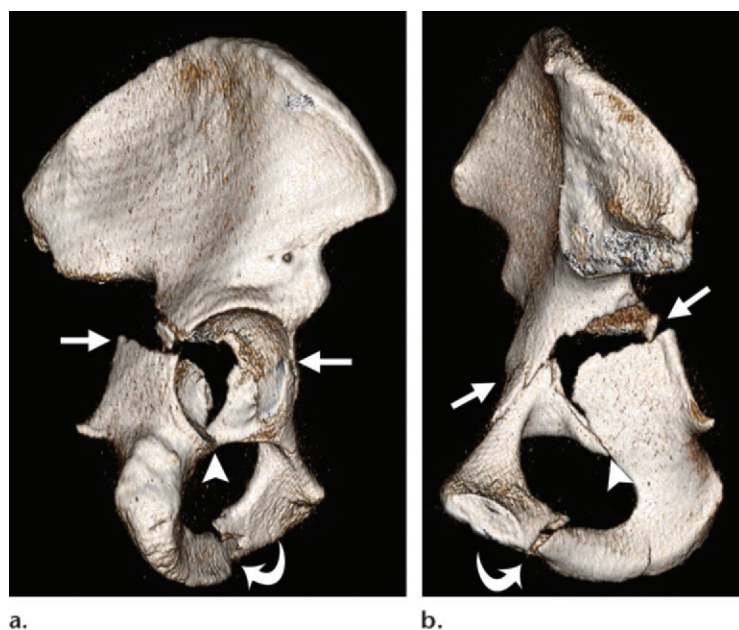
T-shaped acetabular fracture in a 40-year-old man. Lateral (a) and medial (b) 3D surface-rendered CT images show a transverse acetabular fracture (straight arrows), the anterior portion of which is nondisplaced. The stem of the T-shaped fracture (arrowhead) extends inferiorly through the acetabular notch and the ischiopubic ramus (curved arrow).
